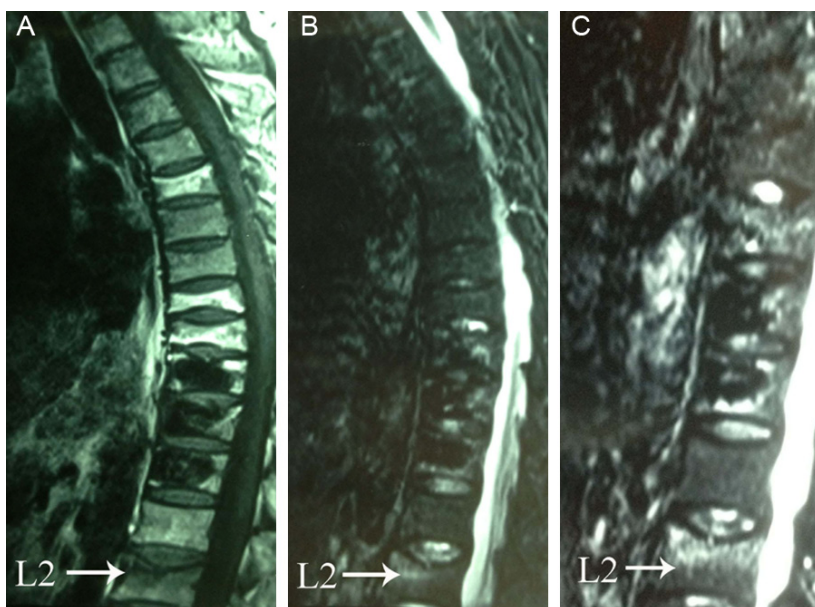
MRI scans on February 8, 2012. MRI scans of L2 vertebral body showed hypointense on T1WI (A), hyperintense on T2WI (B) and STIR (C) sequences. The obvious edema signal is considered as evidence of fresh fracture in painful responsible vertebrae of L2, and healed fracture of T8 is presented with normal signal intensity on T1WI, T2WI and STIR sequences.
